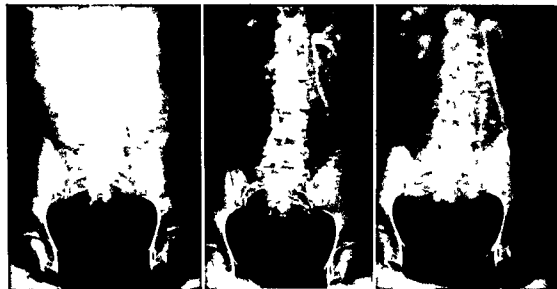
Roentgenogram of primipara, unit history No. 18192. Complaint: acidosis and vomiting. Pyelography at 6 months, uninfected. Excretion periods: 5, 15, and 45 minutes. Best plate: 45 minutes. Dye appears in calyces of both kidneys at 5 minutes. Dense concentration of dye in calyx on right and in calyx, pelvis, and ureter on left at 15 minutes. At 45 minutes, right ureter only dimly outlined; left ureter excellently outlined.
